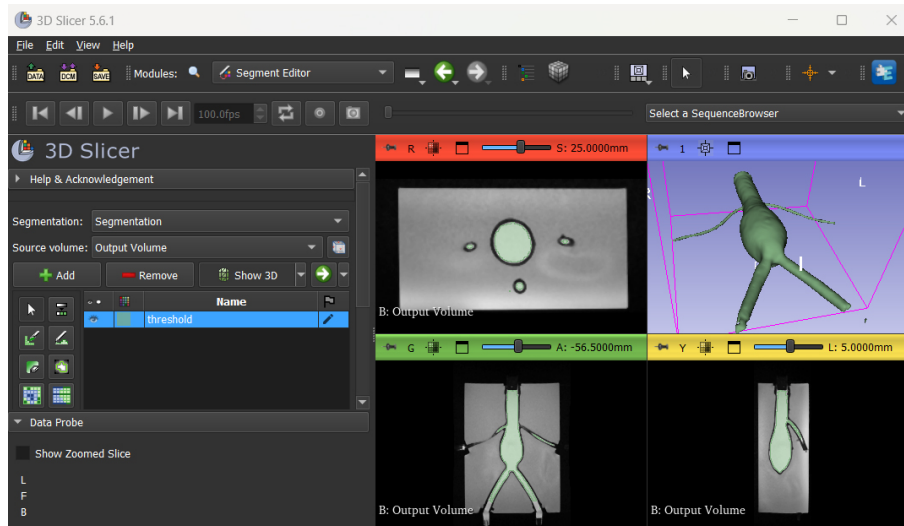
3D Slicer user interface and the generated mesh from the 3D isotropic MRI scan.
